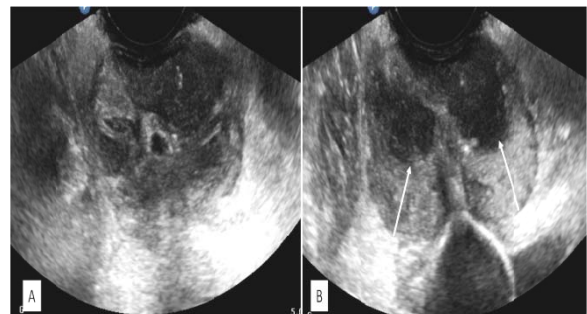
Transrectal Ultrasound (TRUS) Revealed Multiple Small Prostatic Abscesses.
